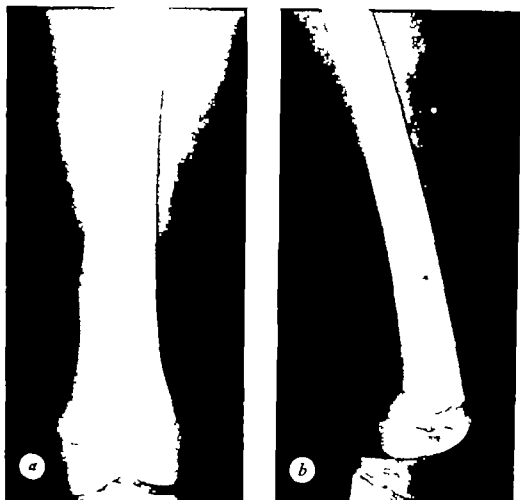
An unusually large fibroma in an 11-year-old girl. Its roentgenologic features, including an appearance of trabeculation, bulging of the cortical outline and a distinct inner boundary are typical. *a* Lateral view of the same lesion makes it appear to be basically central oste. (Roentgenograms of this case were provided through the courtesy of Drs. P. K. Odland, G. L. Thomas and M. B. Llewellyn, of Janesville, Wisconsin.)
